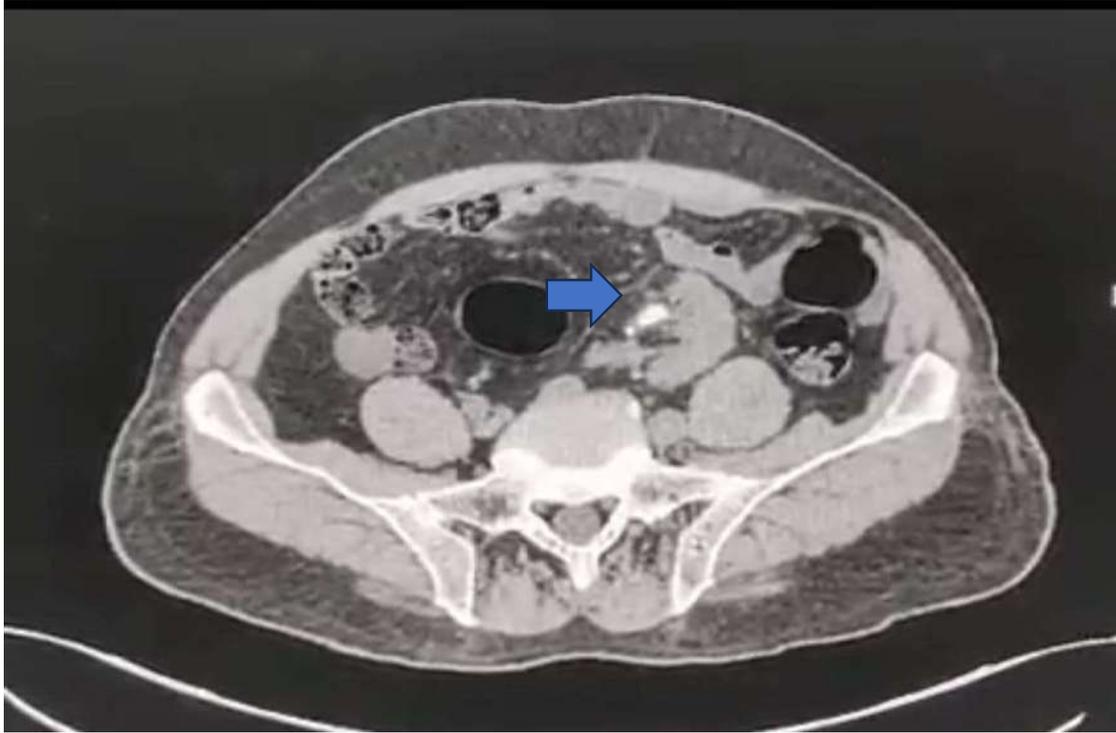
Plain CT-KUB image -axial section showing calculus in the left ectopic pelvic kidney.
